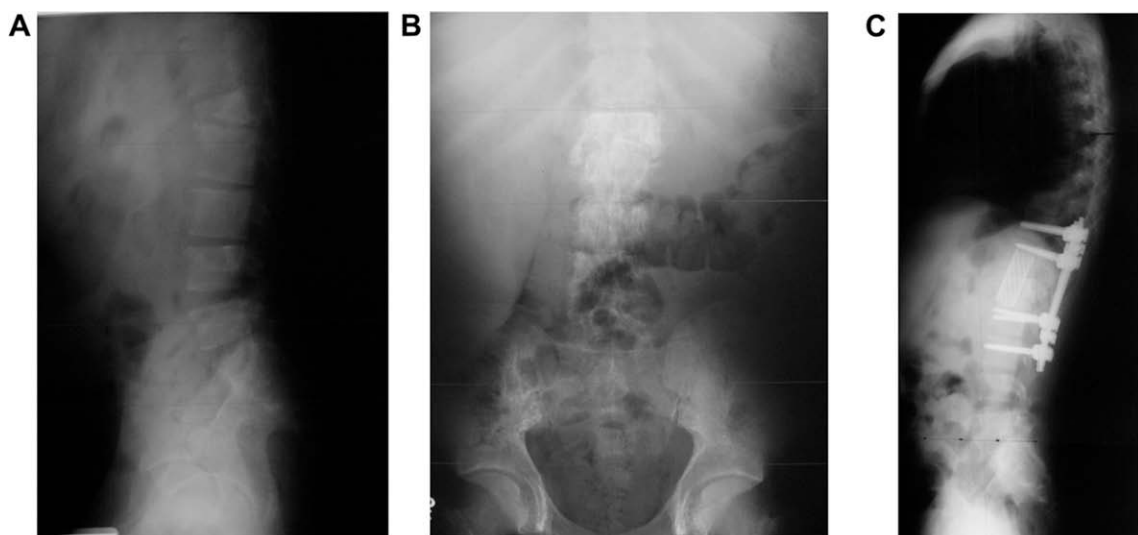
Pre-operative (A) lateral and (B) anteroposterior radiographs of the lumbar spine of a 19-year-old boy showing necrosis, collapse and resorption of the L1 vertebral body. (C) Post-operative lateral radiograph showing the instrumentation and correction of the deformity.
